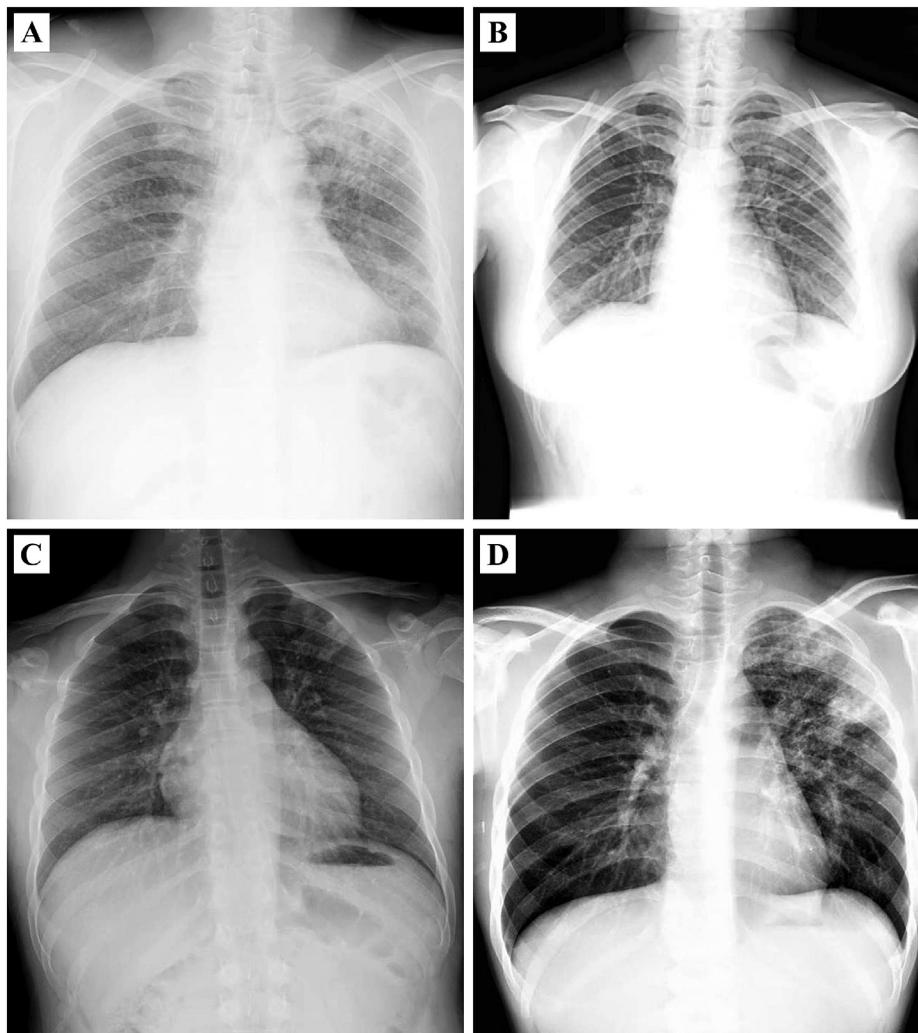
Chest radiographs of four patients with multidrug-resistant tuberculosis: (A) Case 1, (B) Case 2, (C) Case 3, and (D) Case 4.
